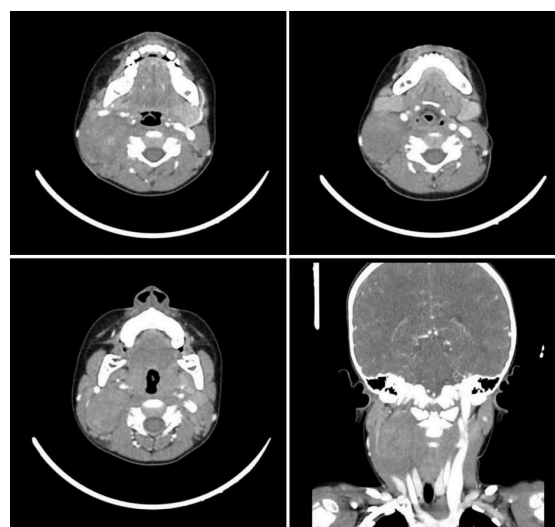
CT Scan Imaging
